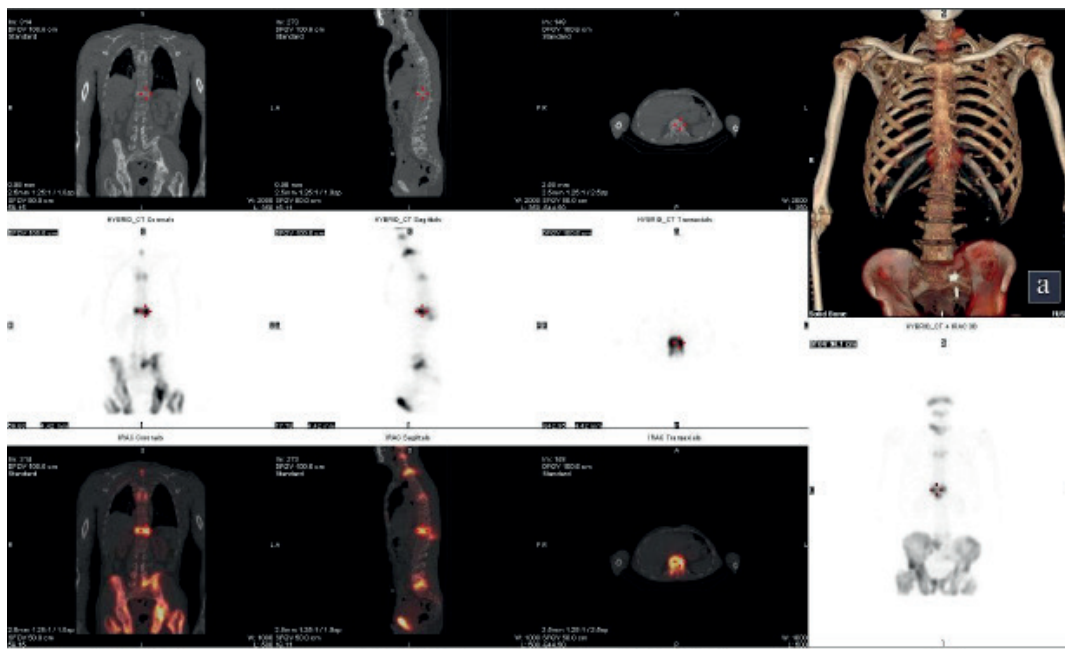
SPECT/CT of the spine.
